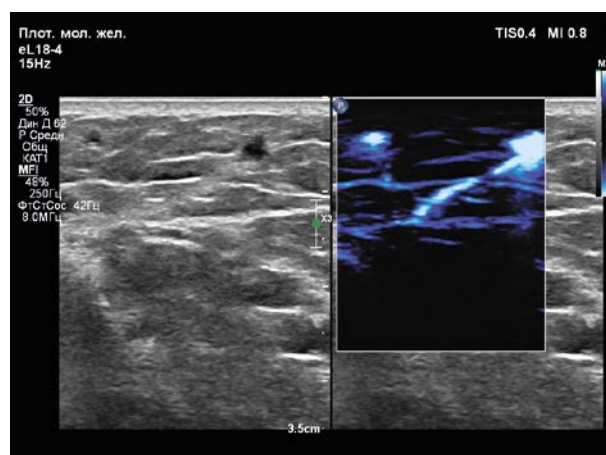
Image of the microvascular network of perforant vessels in the energy Doppler mode at a broadband frequency range of 4-18 MHz when selecting appropriate vessels for moving the flap.
